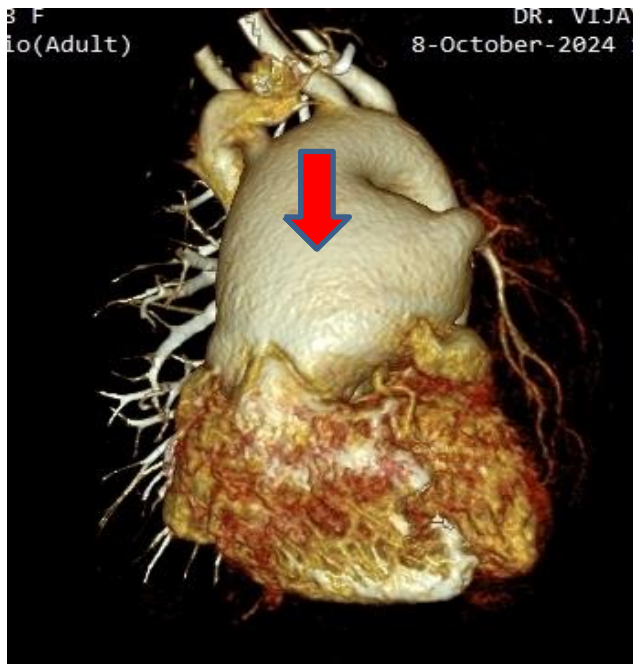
& 5B -Volume rendered 3D CT showing common trunk (Red Arrow) & origin of Right Pulmonary artery from posterior part of trunk(black arrow).
